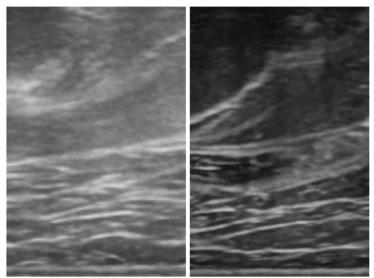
Patient A: ultrasound scan, before and after.
